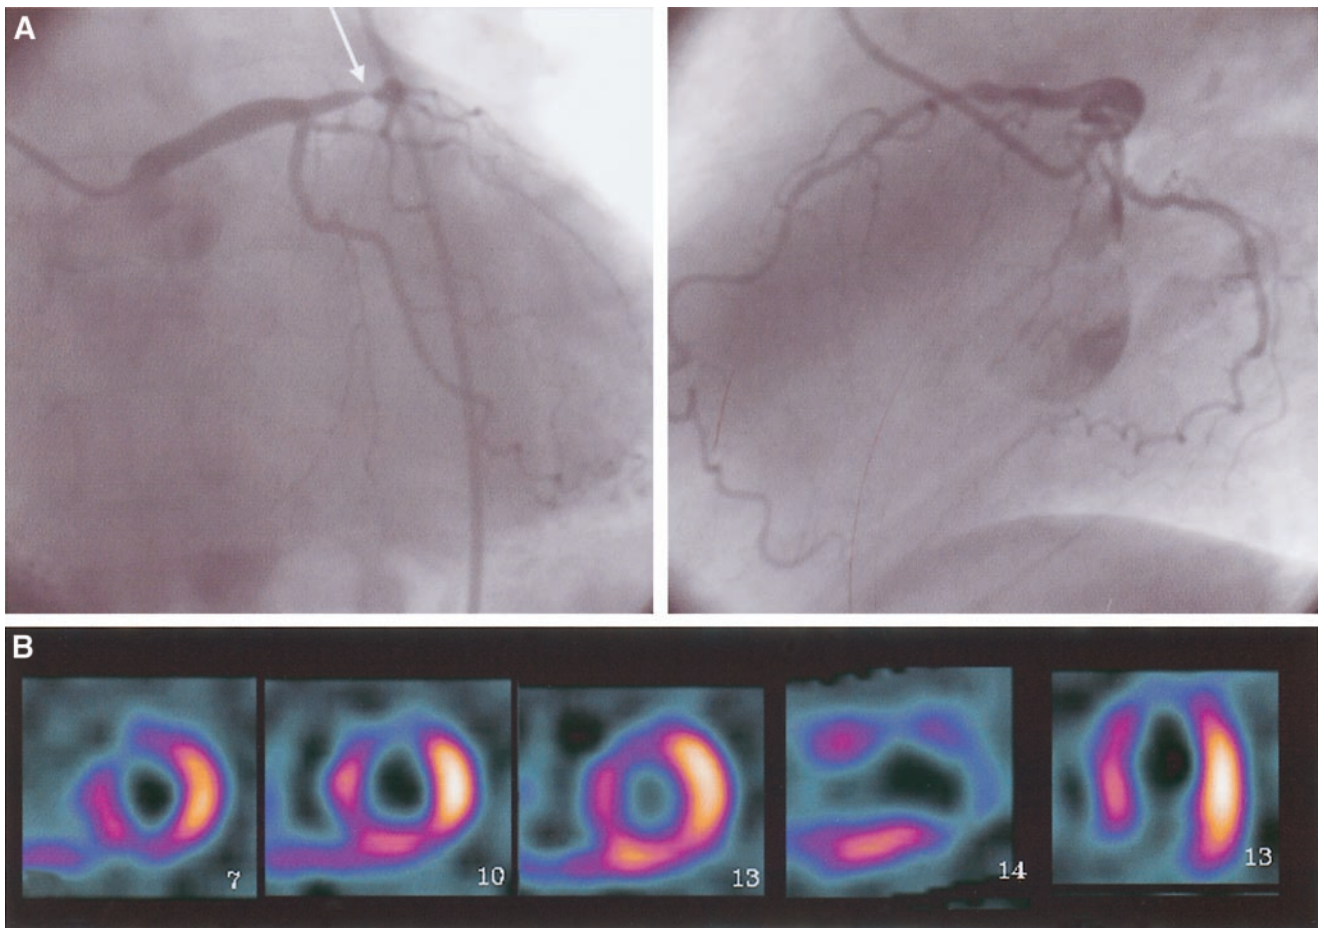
(A) Biplane coronary angiograms from patient with left anterior descending artery (LAD) stenosis. Location of stenosis is marked with arrow. (B) Original SPECT perfusion images of same patient as in A, with radionuclide injected during total balloon occlusion of LAD. SPECT images are serial short-axis slices taken from near the apex (left) through the basal left ventricular region (middle), vertical long-axis, and horizontal long-axis sections. A large perfusion abnormality is seen in anterior and septal walls of left ventricle.
